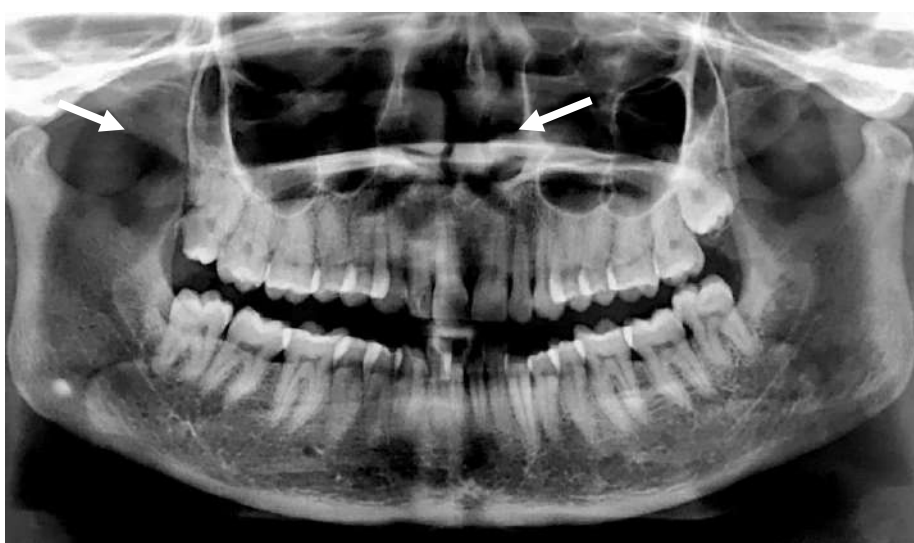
Panoramic radiograph, White arrows showing maxillary sinuses
